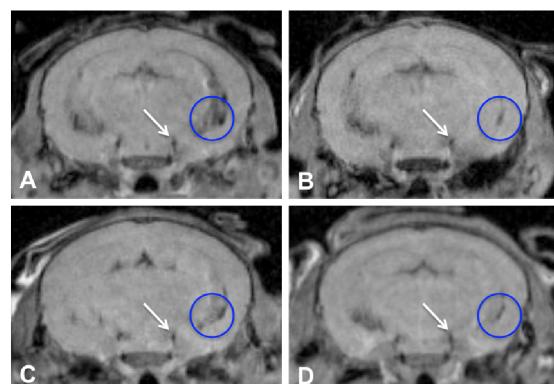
In vivo* MR images of EAE brain post at days 1 (A), 5 (B), 15 (C), and 30 (D) post transplantation. Imaging parameters: TR = 1400 ms, TE = 15.6, matrix = 128 x 128 x 32, FOV = 1.4 x 1.4 x 1.2, acquisition time 24 min.
